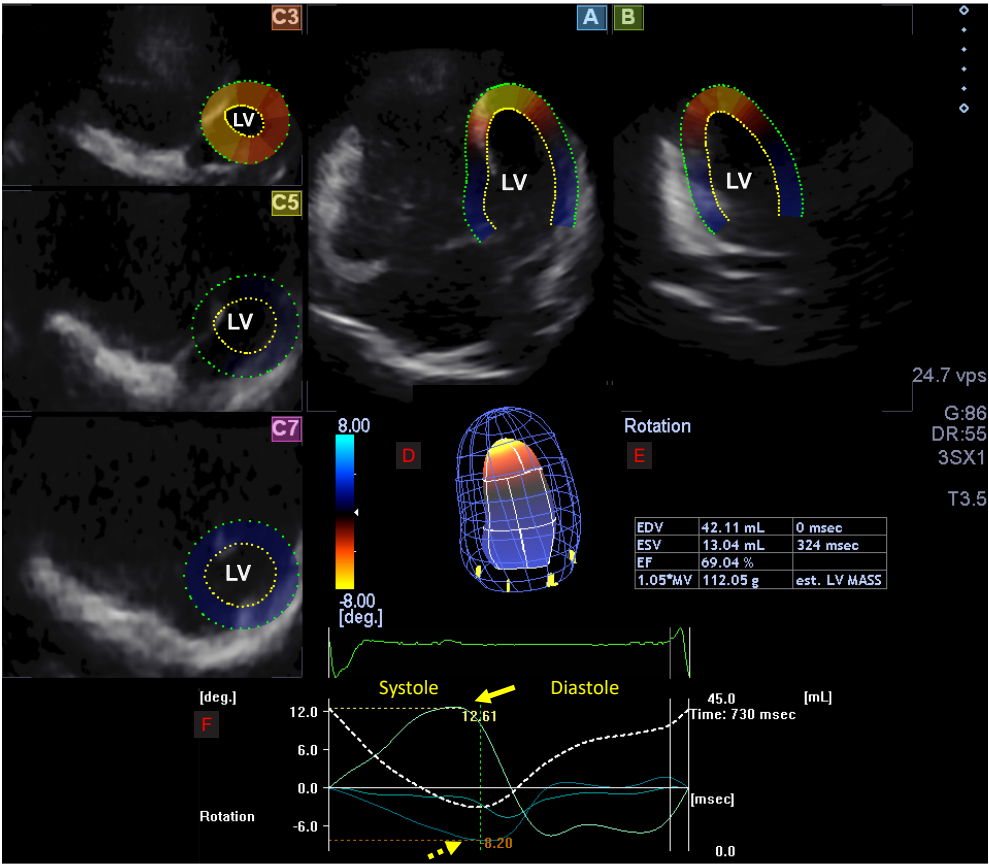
Three-dimensional (3D) speckle-tracking assessment of left ventricular (LV) apical and basal rotations from an LV focused view in a patient with corrected transposition of the great arteries. Apical four-chamber (A) and two-chamber views (B) and basal (C3), midventricular (C5) and apical (C7) short-axis views are demonstrated, that can be automatically extracted from the acquired 3D echocardiographic database. (Red D) shows 3D model of the LV, while (red E) shows LV volumetric parameters and ejection fraction. (Red F) shows apical and basal LV rotations. Yellow arrow represents counterclockwise LV apical rotation, while dashed yellow arrow represents clockwise basal LV rotation.
